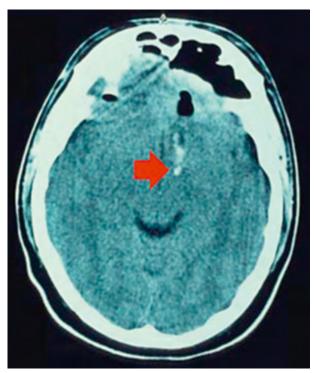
Postoperative axial CT-scan following seemingly uneventful routine paranasal sinus surgery. Obviously a major skull base perforation has happened and a piece of bone (red arrow) was transferred into the remote brain tissue. The surgeon noticed an increased intraoperative blood loss only.
